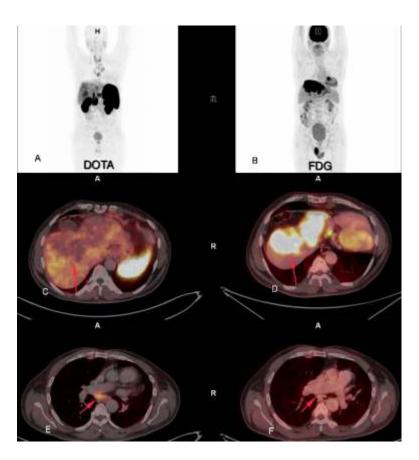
(A-F): 70-years man, a known case of well differentiated NET (G3) underwent dual tracer imaging with 68Ga-DOTATOC and 18F-FDG. MIP images (A and B) show subtle somatostatin uptake in the liver and higher somatostatin uptake in the mediastinum (A) and higher FDG uptake in the liver and subtle uptake in the mediastinum (B). Axial fused PET/CT images (C, D) show subtle somatostatin tracer uptake (arrow in C) and higher FDG uptake (arrow in D) in the liver lesions. Axial fused PET/CT images (E, F) show higher somatostatin uptake (arrow in E) and subtle FDG uptake (arrow in F) in the subcarinal mediastinal lymph node.
